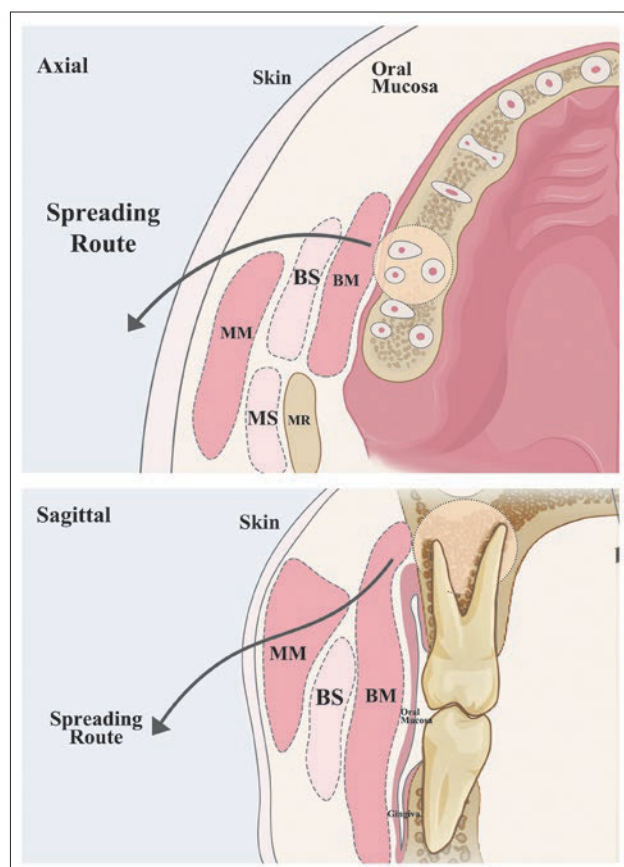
Potential route for spreading of the periapical abscess in the present case. BM, buccinator muscle; BS, buccal space; MM: masseter muscle; MR, mandibular ramus; MS, masticator space.
